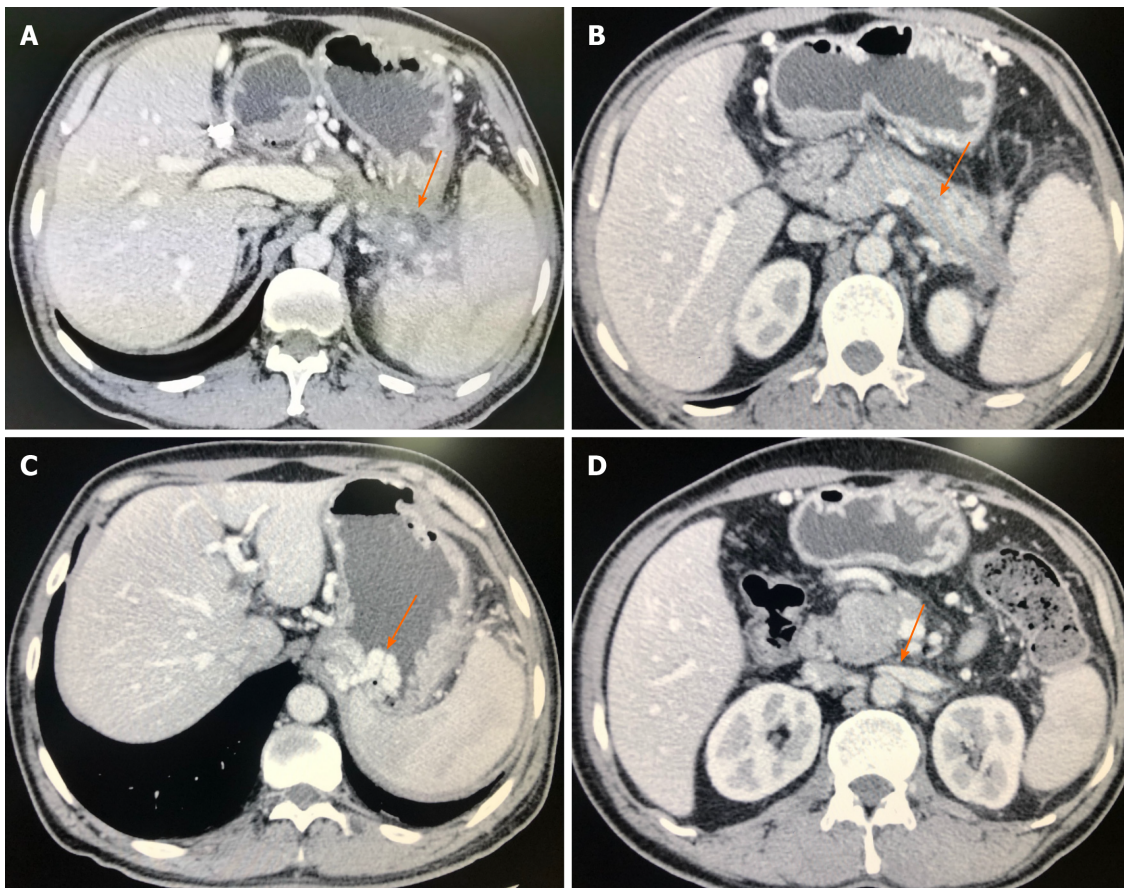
Contrast-enhanced computed tomography imaging. Appeared as (arrows): A: Pancreatic pseudocysts; B: Main splenic venous thrombus; C: The development of gastric varices; D: The compression of left renal vein.
